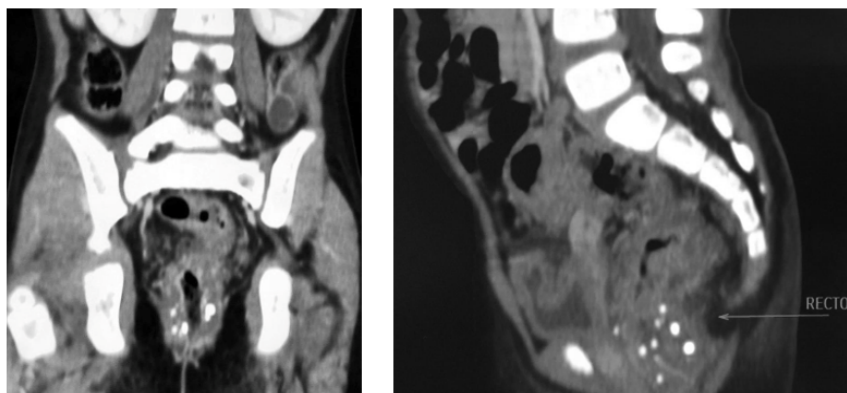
CT of the rectum showing intramural phleboliths.
